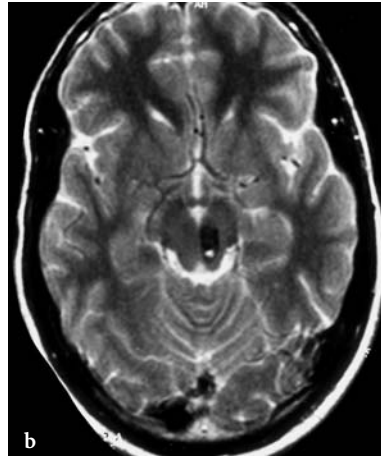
A 20-year-old man with acute left-sided NIII paresis and right hemiparesis. Diagnosis: tegmental cavernoma. CT: a Axial native view with slightly calcified hyperdense focus in the medial left cerebral peduncle. MR: b Corresponding T2-weighted view with characteristic hypointensity of hemosiderin deposit/calcification and hyperintensity of the cavernous space. c Corresponding T1-weighted, contrast-enhanced image with signal enhancement of the venous area. d Paramedian sagittal T1-weighted, contrast-enhanced cut, demonstrating localization of the cavernoma in the medial tegmentum. (With permission of Dr. Müller-Forell, Institute of Neuroradiology, Medical School, Mainz)
